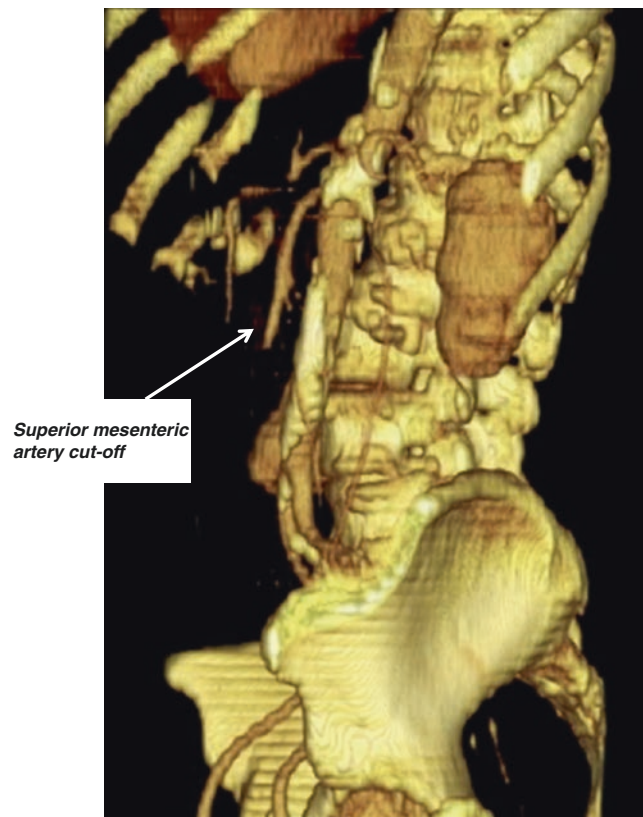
CT angiogram VTR view of abdomen revealing occluded superior mesenteric artery
